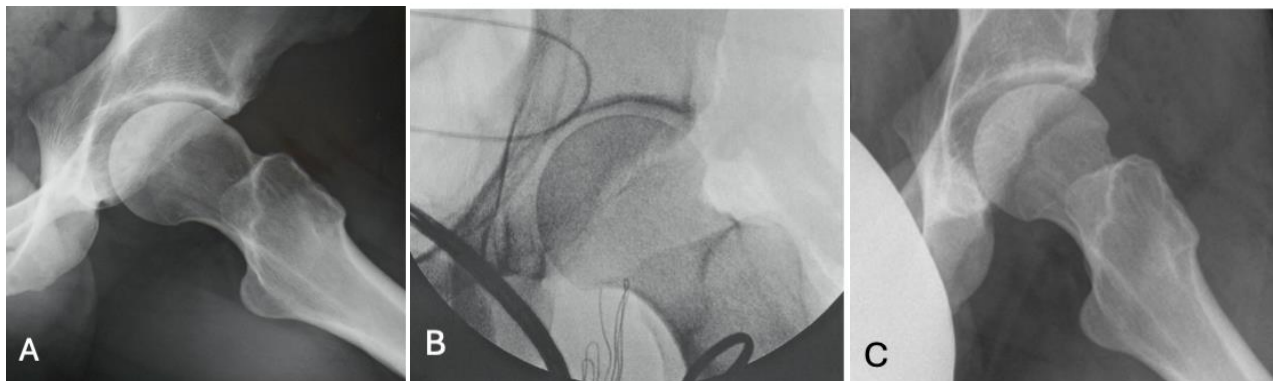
Radiographic images of 31 years old male patient. A): pre-operative CAM deformity. B): intraoperative fluoroscopy for assessment of CAM correction. C): X-ray of the hip at latest follow-up.
